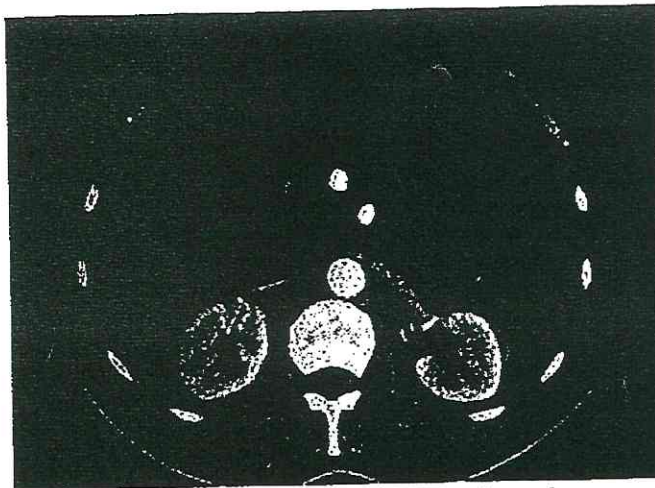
In the CT, the partially thrombosed pseudoaneurysm of 2.5 cm in size with intensive contrast fixation observed at the gastroduodenal artery causes shifting of the superior mesenteric artery laterally.
